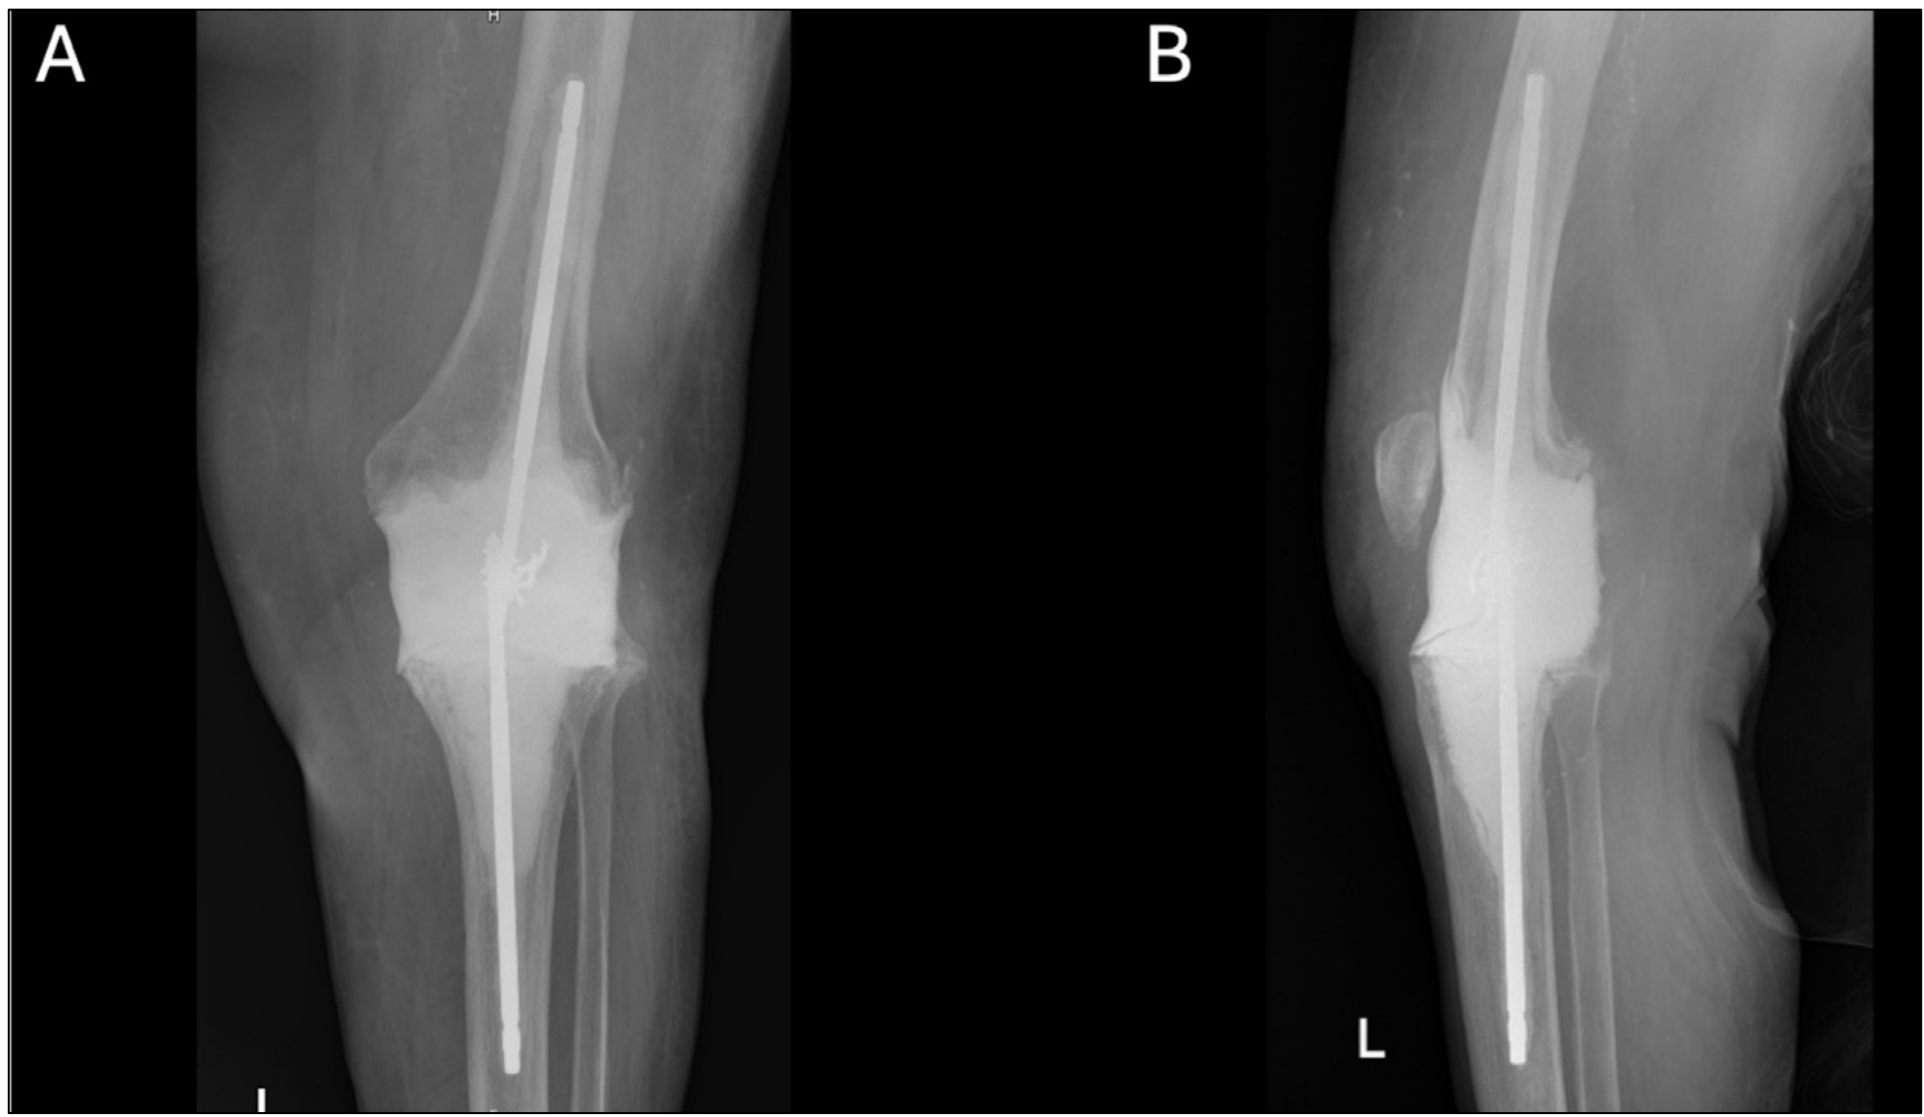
Static antibiotic-loaded cement spacer : (A) anteroposterior and (B) lateral X-ray maintaining limb length, alignment, and soft-tissue tension.
